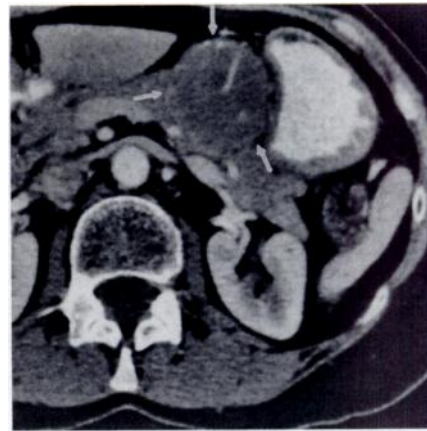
65-year-old woman with myeloma manifested by a pancreatic mass. Biopsy of mass showed plasma cell tumor. CT scan of abdomen shows a well-demarcated, hypervascular mass (arrows) arising from body of pancreas.
